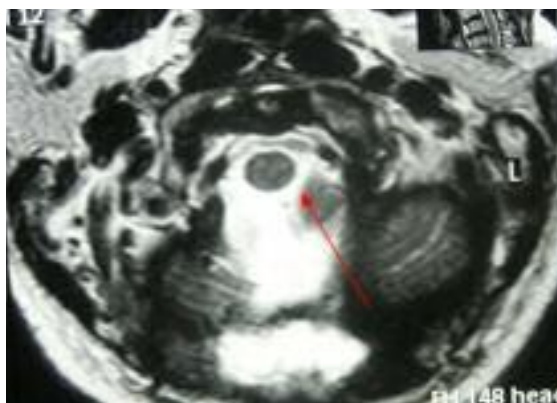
Postoperative axial T2-weighted MRI. Note the absence of the mass effect (red arrow).
